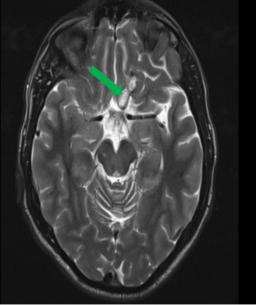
Axial sections of T2-weighted sequence showing that the lesion extended intimately into the frontal subarachnoid spaces (Red arrow) and the opto-chiasmatic cistern (green arrow) and was in close contact with the left optic nerve in its prechiasmatic segment.
